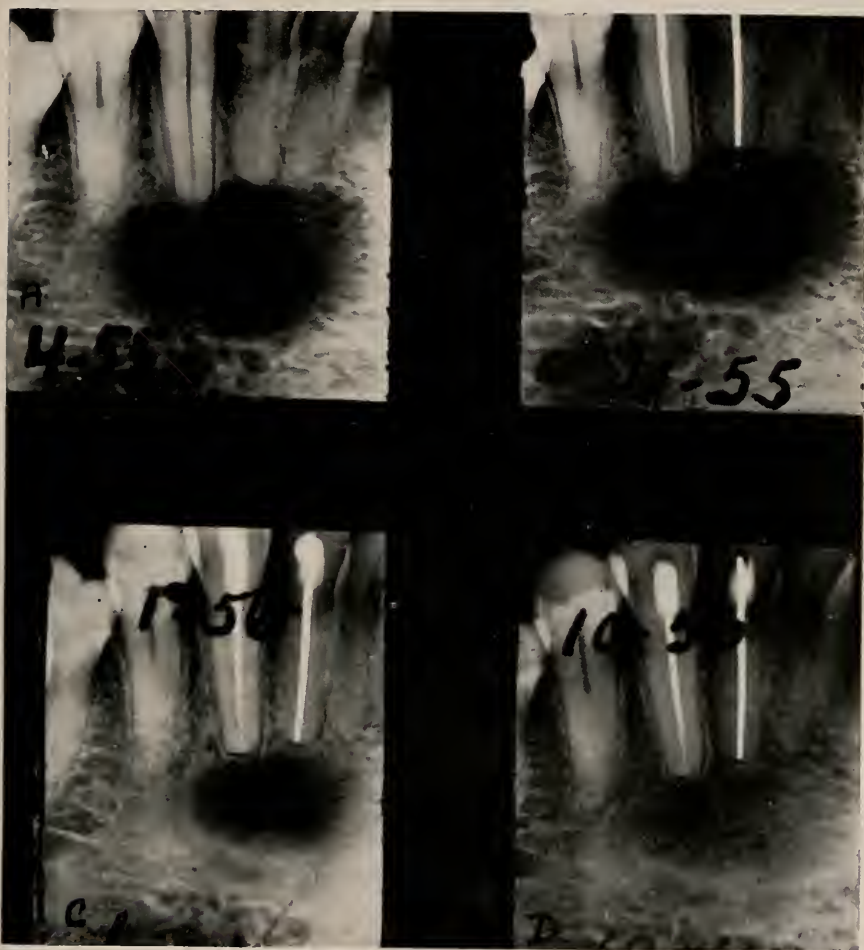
Case 1. Fibrous dysplasia. A. Diagnostic x-ray prior to treatment. B. X-ray following endodontic treatment. C. Seven months post surgical treatment. D. Eighteen months following initial treatment.
